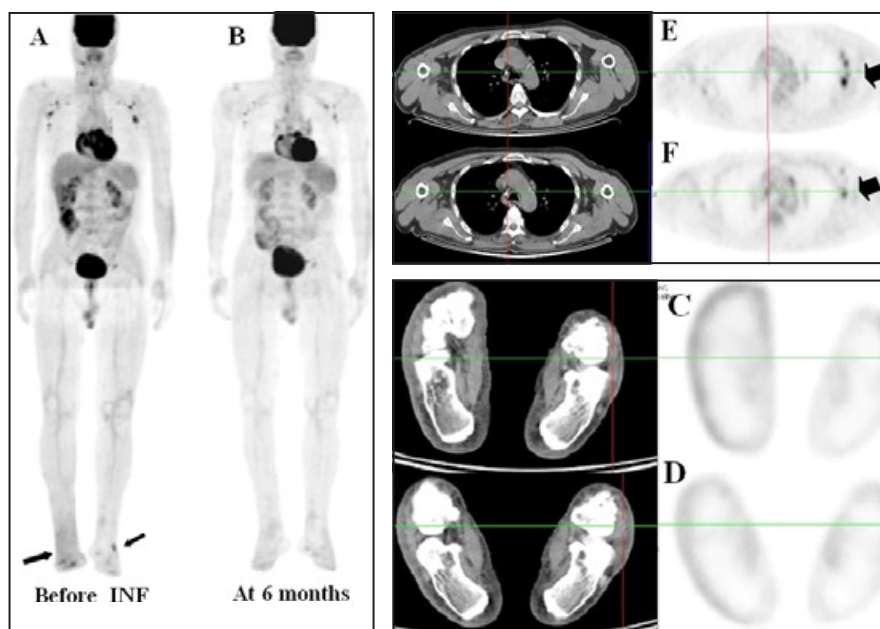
First case: Fluorine-18-FDG-PET image A and B: Anterior position of maximum intensity projection (MIP) image C: Axial section at the level of heel before the initiation of INF treatment. Multifocal increased dermal and subdermal ^{18}F -FDG uptake was demonstrated in the distal parts of bilateral lower extremities (arrows in A and C). A control PET scan after 6 months, B: Anterior MIP image D: Axial view at the level of heel revealed decreased uptake indicating metabolic response to INF treatment. Unexpected bilateral ^{18}F -FDG positive axillary lymphadenopathies were demonstrated (arrow, E). After 6 months, diminished uptake was shown in both axillary regions (arrow, F) and no pathological uptake was observed on both feet (D).
